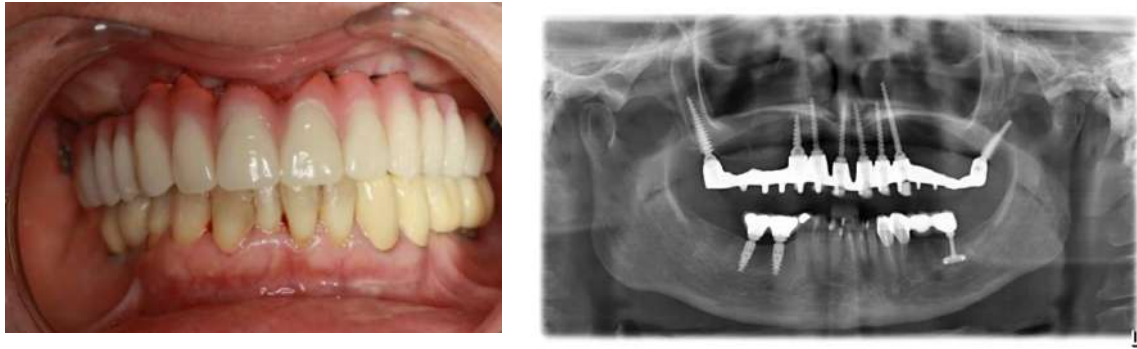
Clinical photograph and the panoramic radiograph of patient and after bridge delivery
